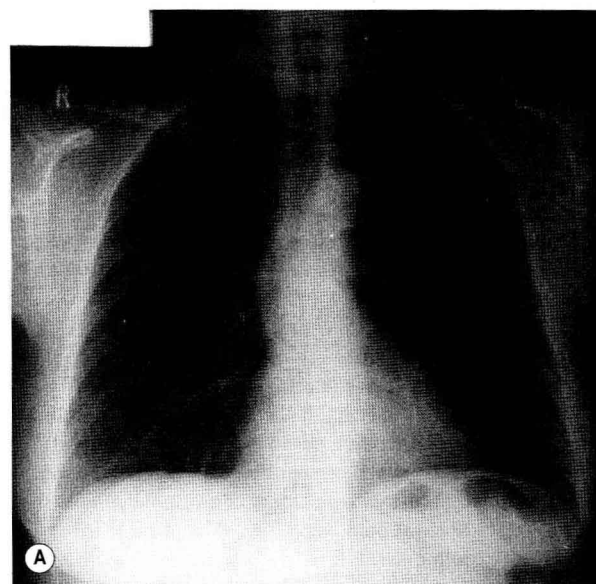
Normal anteroposterior chest X-ray.
